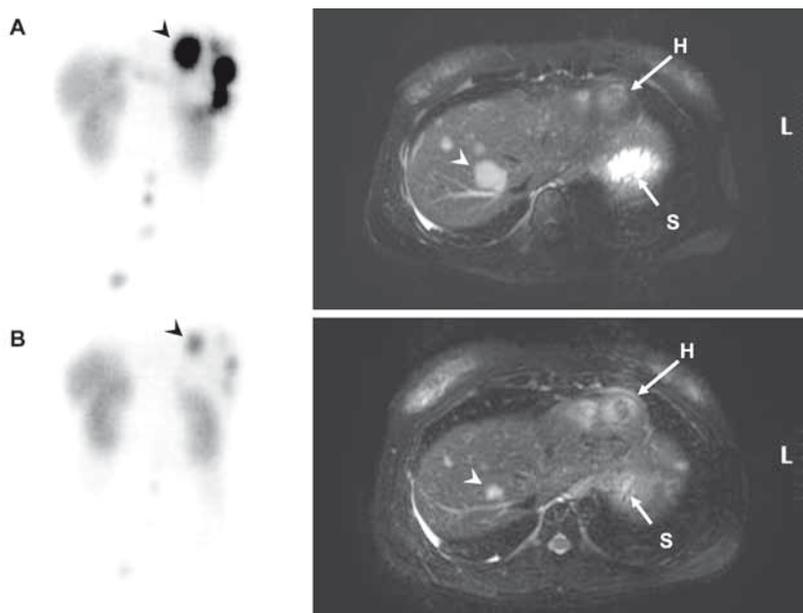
Treatment response with ^{177}Lu -octreotate in a patient with a metastasised bronchial carcinoid (H heart, S stomach). (A) Scintigraphy 24 h after the first dose of ^{177}Lu -octreotate (left panel) and MRI 6 weeks before starting treatment (right panel): the arrowhead indicates one of multiple liver metastases. (B) Scintigraphy 24 h after the last dose of ^{177}Lu -octreotate (left panel): the arrowhead indicates decrease in uptake in one of the liver metastases. MRI 5 months after finishing the treatment (right panel) visualises tumour regression (arrowhead)
